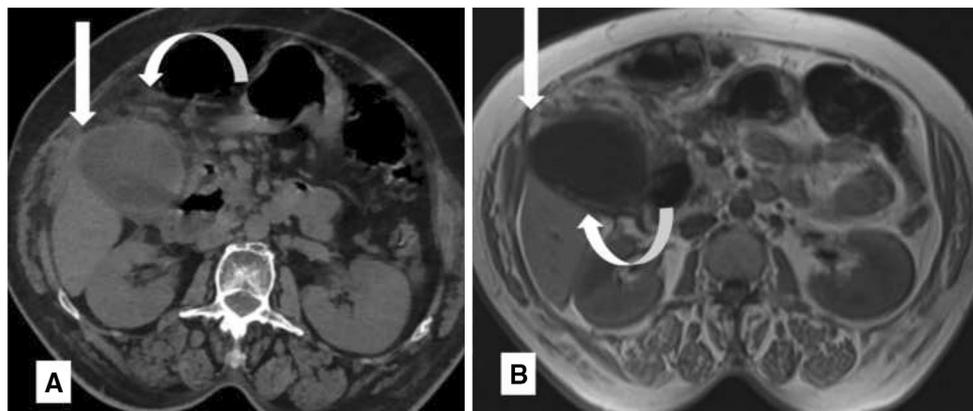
Axial CT a shows distended non flattened gall bladder fundus indenting the overlying anterior abdominal wall (straight arrow) with pericholecystic fat stranding (curved arrow). Axial MRI T1 weighted image b shows distended non
